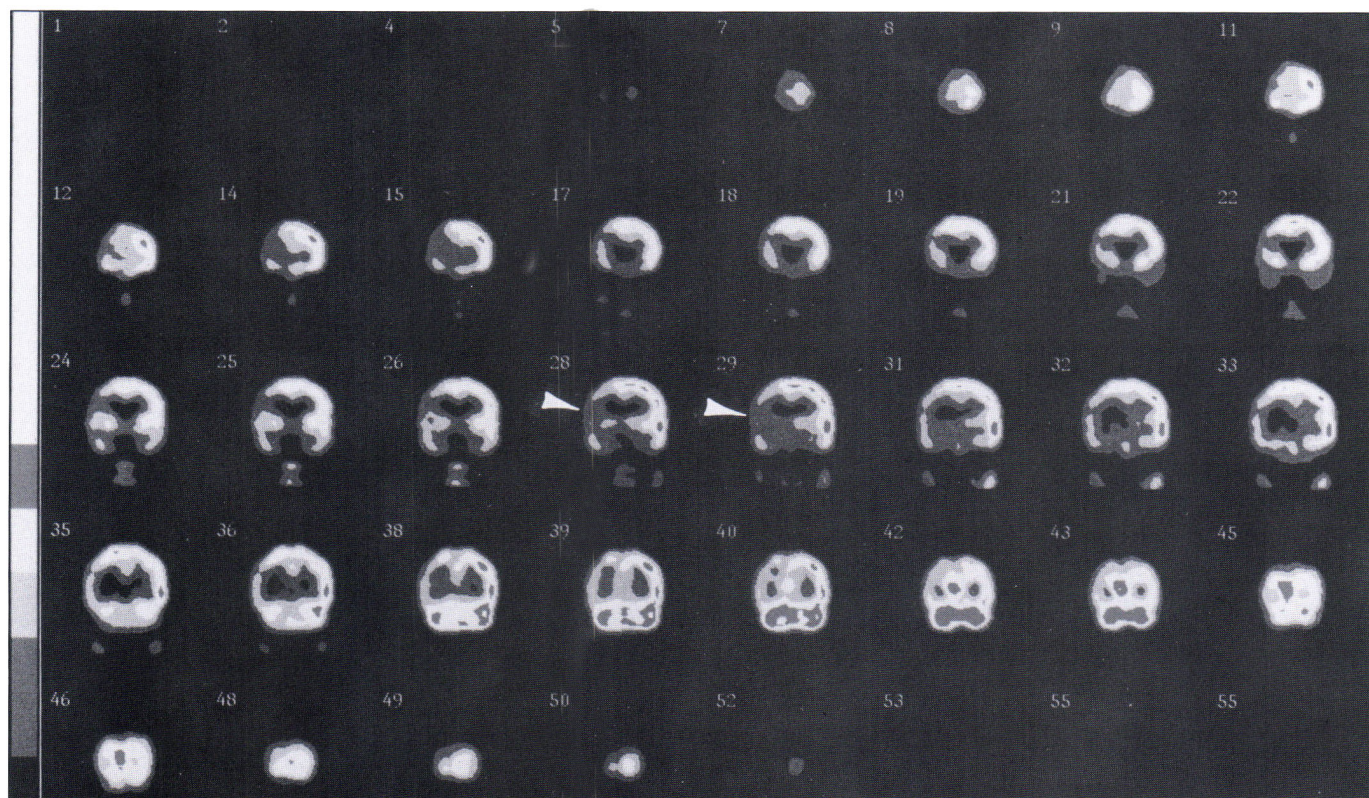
Interictal  $^{99}\text{Tc}$ -HMPAO/SPECT imaging in coronal plane reveals substantial reduction in perfusion of the right temporal and parietal lobes (arrowheads).
